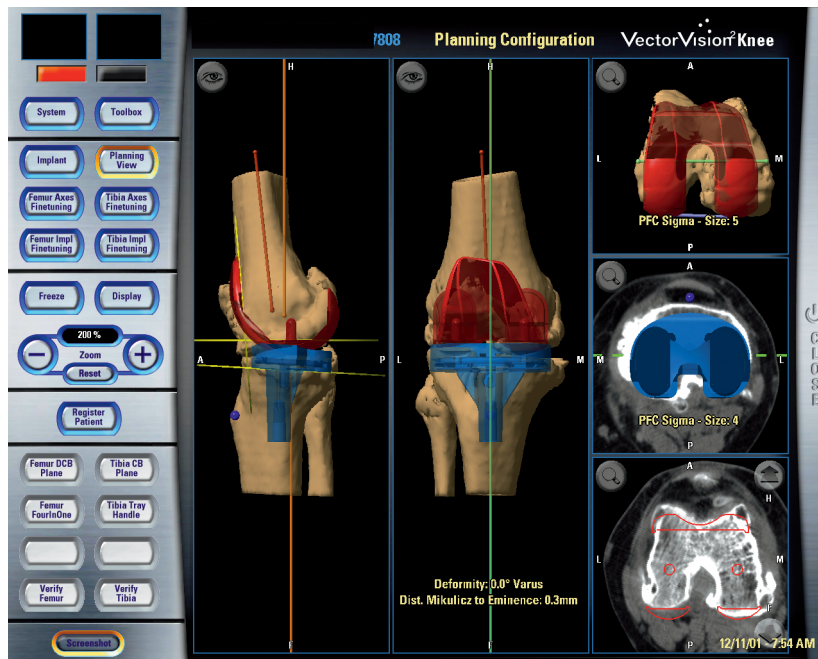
The preoperative planning can be performed either in the original CT data or in a 3-D model. It provides further information about the rotation of the components and necessary bone resections.
